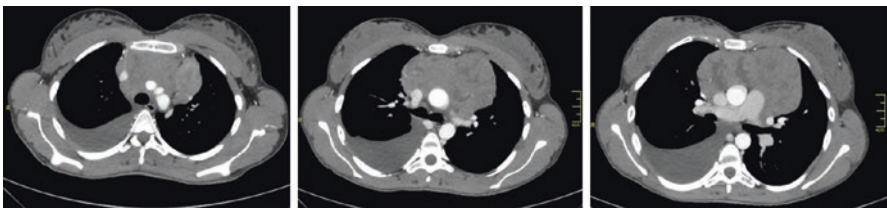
Chest CT with contrast: non-Hodgkin lymphoma B cells of the thymus. There is an inhomogeneous, partly colligated mass located in the anterior mediastinum. AR: right pleural effusion is observed
